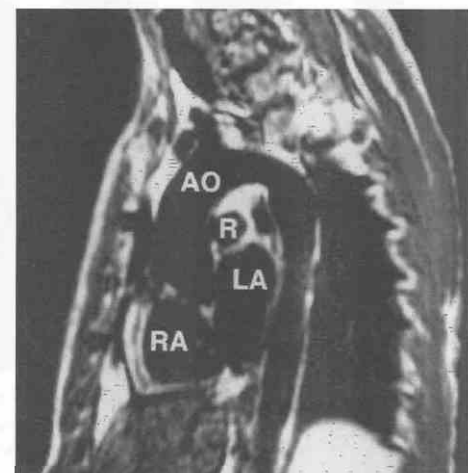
Sagittal MR image of the aorta. AO, aorta; LA, left atrium; R, right pulmonary artery; RA, right atrium.
